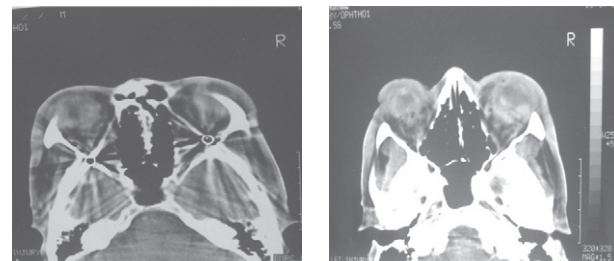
CT Scan orbit (axial sections) : showed well defined hyperdense pellets at the orbital apices with deformed globes showing haemorrhage. Multiple streaky opacities are seen in the retro-orbital fat suggesting haemorrhages. Optic nerves are not well defined suggesting contusion / avulsion of the optic nerves
